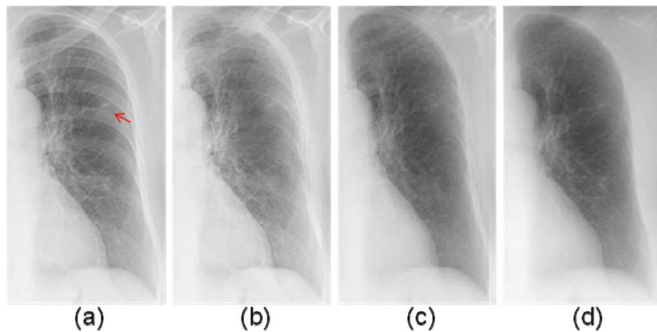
Results for abnormal chest radiographs with a tiny nodule in the left lung. (a) An original abnormal chest radiograph with a nodule (indicated by a red arrow), (b) a VDE soft-tissue image obtained by use of our original MTANN technique, (c) a VDE soft-tissue image obtained by use of our new MTANN technique, and (d) the corresponding “gold-standard” dual-energy soft-tissue image.
